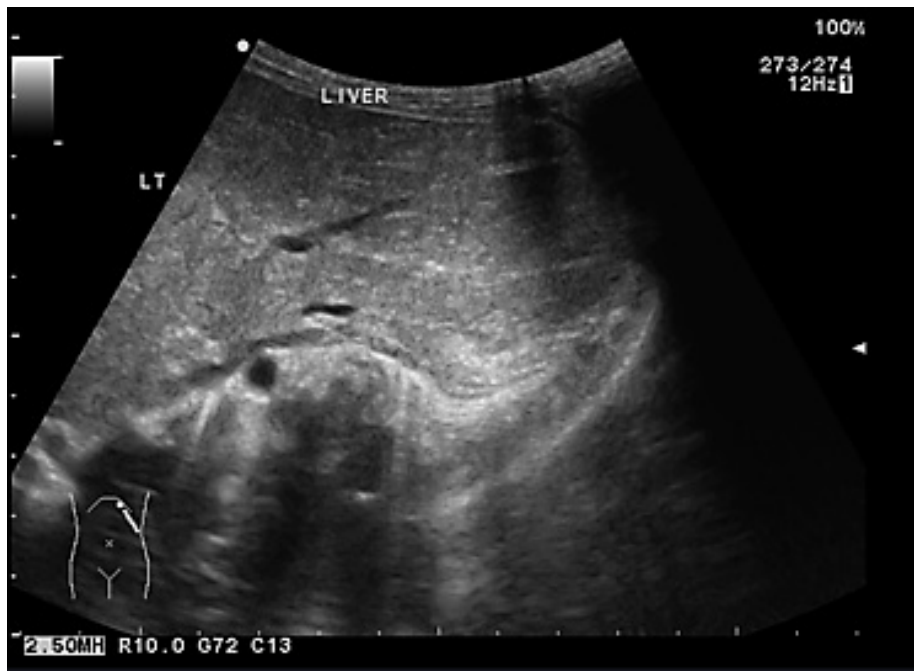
Ultrasound scan showing liver located on the left
